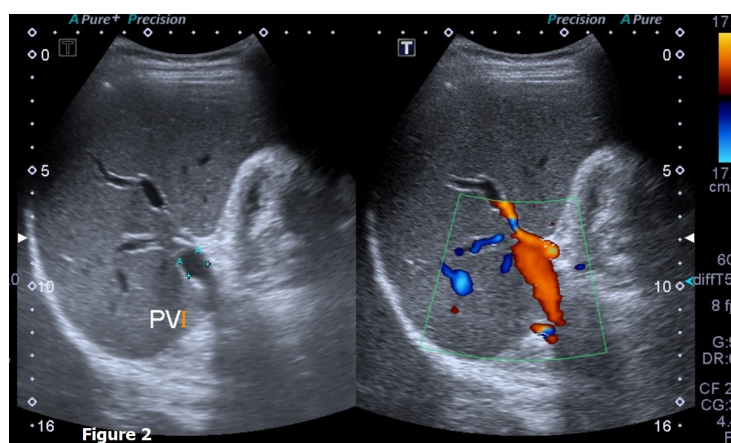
Colour Doppler ultrasound of the portal system which shows patent portal vein with normal Doppler flow.
